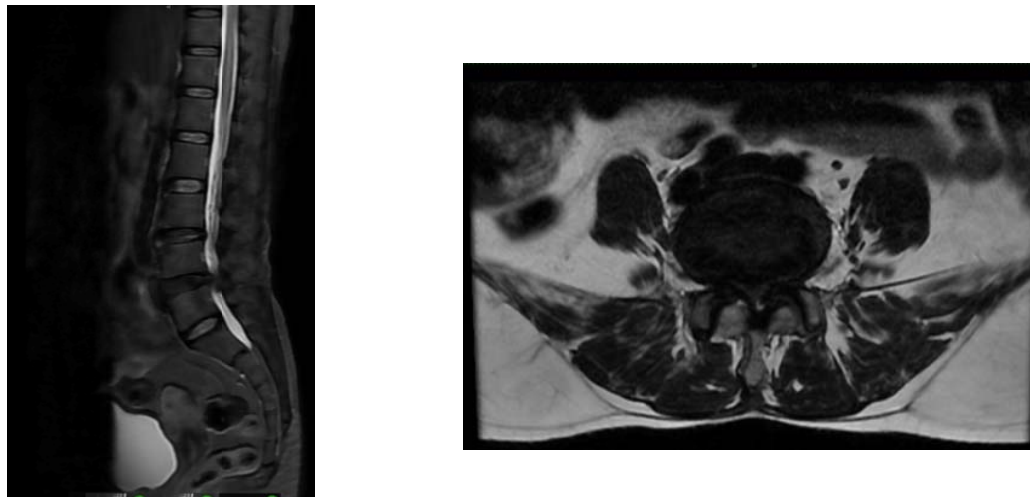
Sagittal T2-weighted and Axial T2-weighted images demonstrates Anterior endplate osteophytes involving all lumbar vertebrae. Diffuse disc bulge at L2-L3 and L5-S1 level causing ventral thecal sac indentation and no neural compromise. Diffuse disc bulge with posterocentral annular tear at L3-L4 level causing ventral thecal sac indentation and bilateral neural foraminal narrowing and mild spinal canal narrowing causing indentation of right and compression of left exiting nerve roots. Bilateral facet joint arthrosis. Diffuse disc bulge at L4-L5 level causing ventral thecal sac indentation and bilateral neural foraminal narrowing and lateral recess narrowing causing indentation of right traversing L5 and compression of bilateral L4 exiting nerve roots. Bilateral facet joint arthrosis noted.
